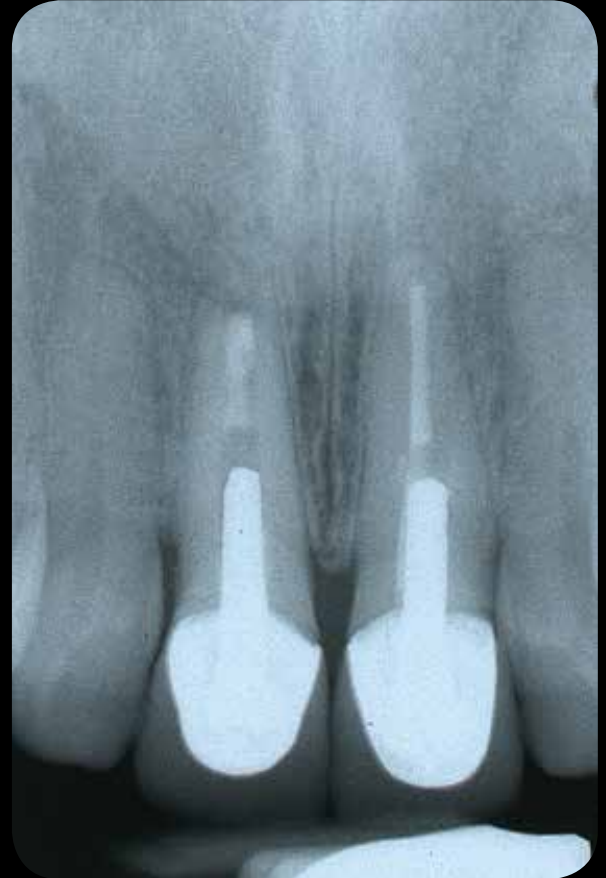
Although #8 and #9 were asymptomatic, a preoperative radiograph indicates a failing endodontic treatment and less-than-adequate marginal integrity on the crown of #8.
